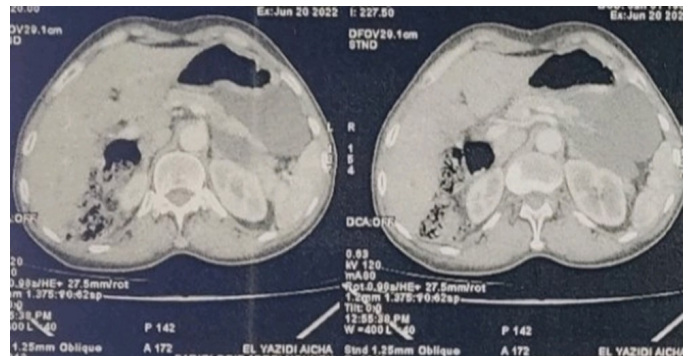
a CT-scan slide showing the retroperitoneal cystic mass.
